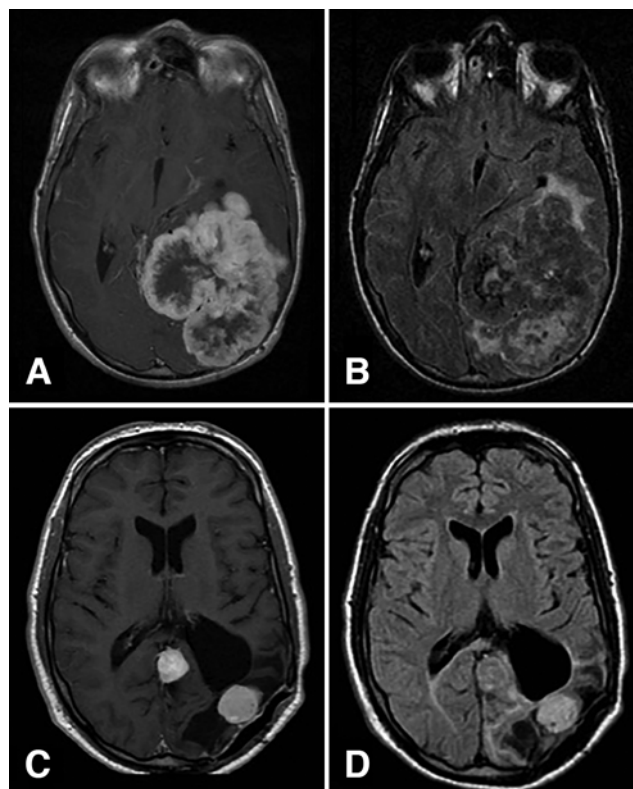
Case 1. MR images obtained before initial surgery (A and B) and at recurrence with progression (C and D). A and B: Axial contrast-enhanced T1-weighted (A) and FLAIR (B) MR images showing a voluminous left parieto-occipital Grade I MSFT/HPC. C and D: Axial contrast-enhanced T1-weighted (C) and axial FLAIR (D) images showing nodules of a Grade III MSFT/HPC. Analyzing the tumor and peritumoral edema on brain MRI did not help in predicting the malignant progression.
